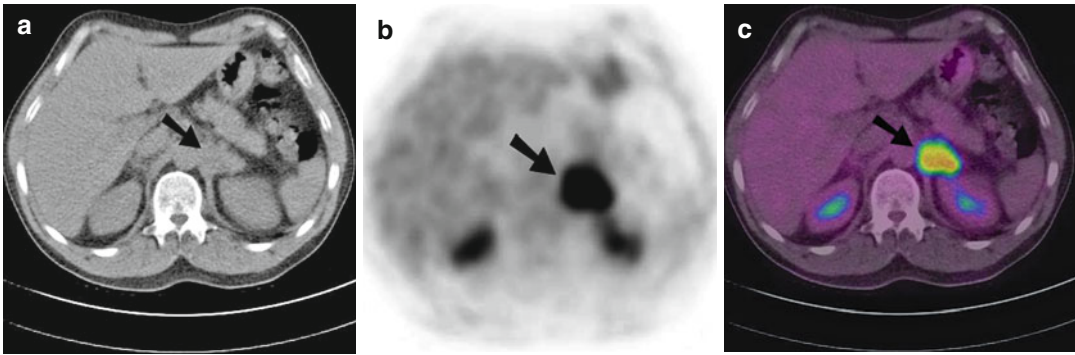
Transaxial CT (a), FDG PET (b) and combined PET-CT (c) images of the upper abdomen of a 55-year-old man with adenocarcinoma of unknown origin. Bilateral adrenal enlargement with abnormal increased FDG was noted. The right adrenal gland measured 30 mm with an SUV_{max} of 4.4 on PET
